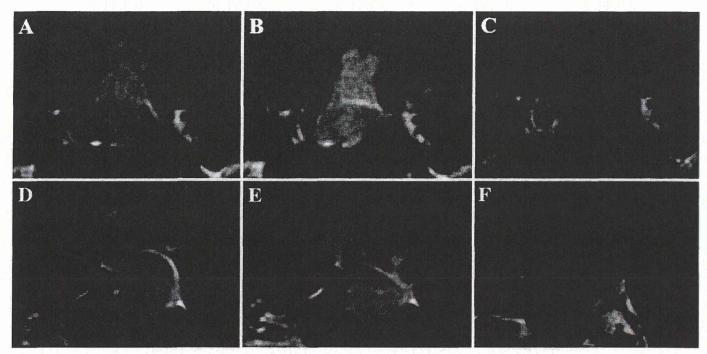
Coronal (A–C) and sagittal (D–F) T1-weighted contrast-enhanced MR images obtained in a 43-year-old man with SITSH and GH hypersecretion. A and D: Initial images show a macroadenoma with suprasellar extension anteriorly. B and E: Images obtained after 2 treatments with a long-acting formulation of octreotide showing tumor shrinkage. The patient's visual disturbance also improved. C and F: Images obtained after complete tumor resection by extended transsphenoidal surgery and normalization of hormone hypersecretion.
